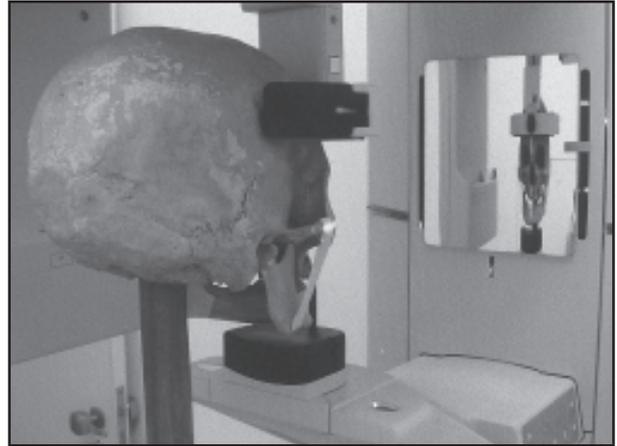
Skull placed on a wooden pole and positioned in the panoramic x-ray machine
